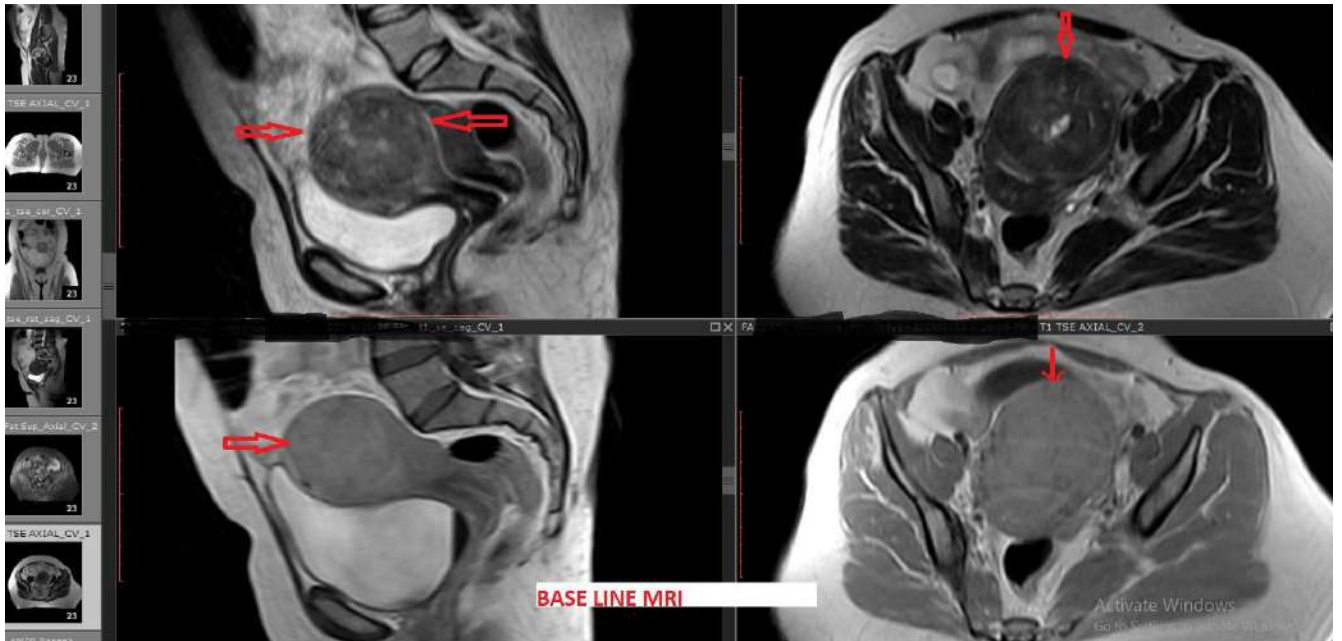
a: MR images showing a solitary large fundal fibroid.
